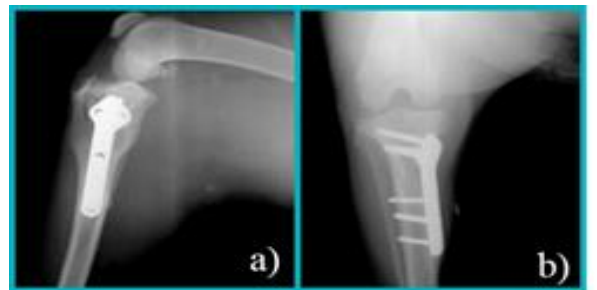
a-Mediolateral b-Craniocaudal radiographical views of the stifle joint on case 8 on post-operative 60<sup>th</sup> day.
